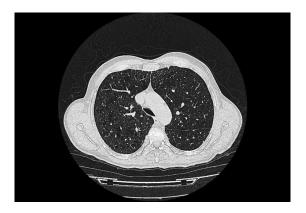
A thoracic computed tomography scan revealed a pulmonary micronodular pattern.
